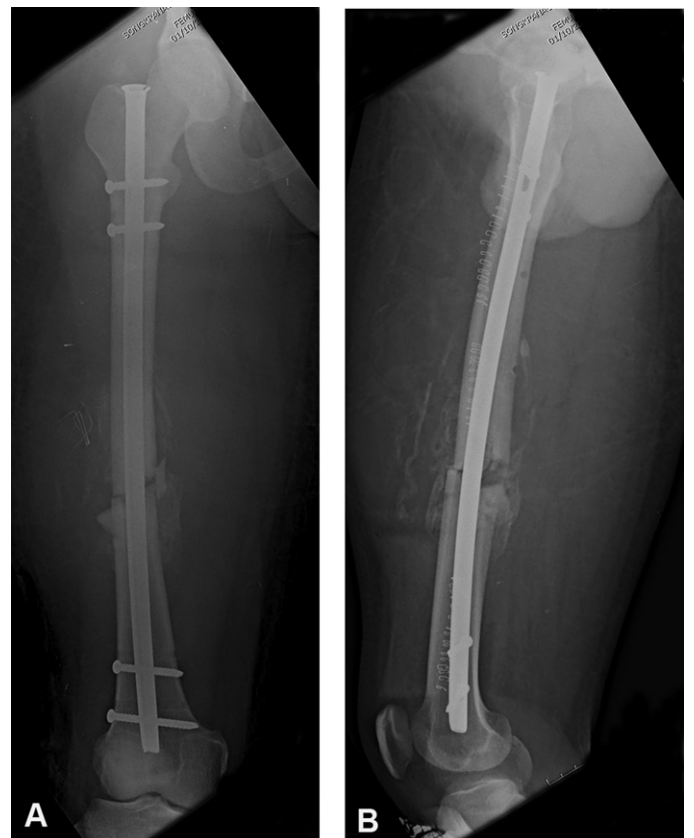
Radiographs showing the exchanged nail without bone grafting (A and B).
